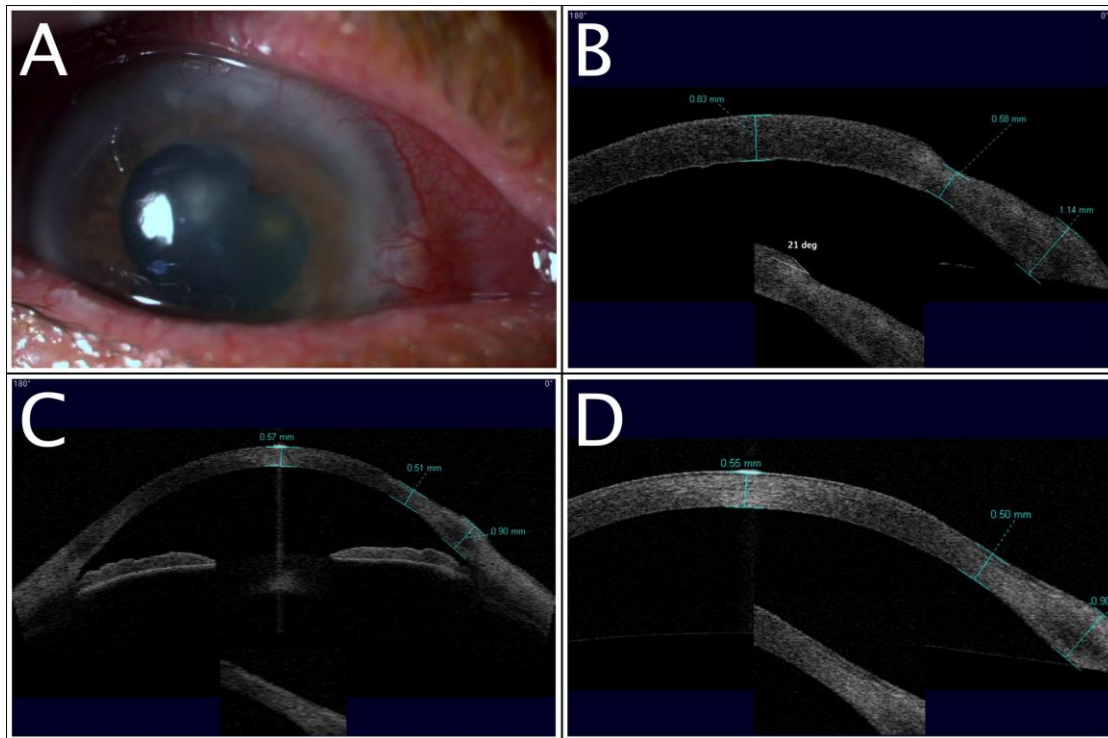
Case 3. Serial AS-OCT scans through peripheral ulcerative keratitis in rheumatoid arthritis. A. Photo at presentation showing active nasal peripheral ulcerative keratitis. B. At presentation, the acute ulcer had walls with a steep gradient, the steepest measuring 21° ; minimum corneal thickness (CT) at the ulcer base was $580\text{ }\mu\text{m}$. The endothelial surface and Descemet's membrane were irregular due to diffuse corneal oedema. C. Following clinical remission, AS-OCT two months from presentation, showed that the CT had decreased at the ulcer base, centrally and peripherally; the Descemet's folds had cleared, suggesting resolution of oedema, and no ulcer was detected. D. Repeat AS-OCT, eight months later, confirmed clinical stability with CT and ulcer characteristics remaining unchanged.
